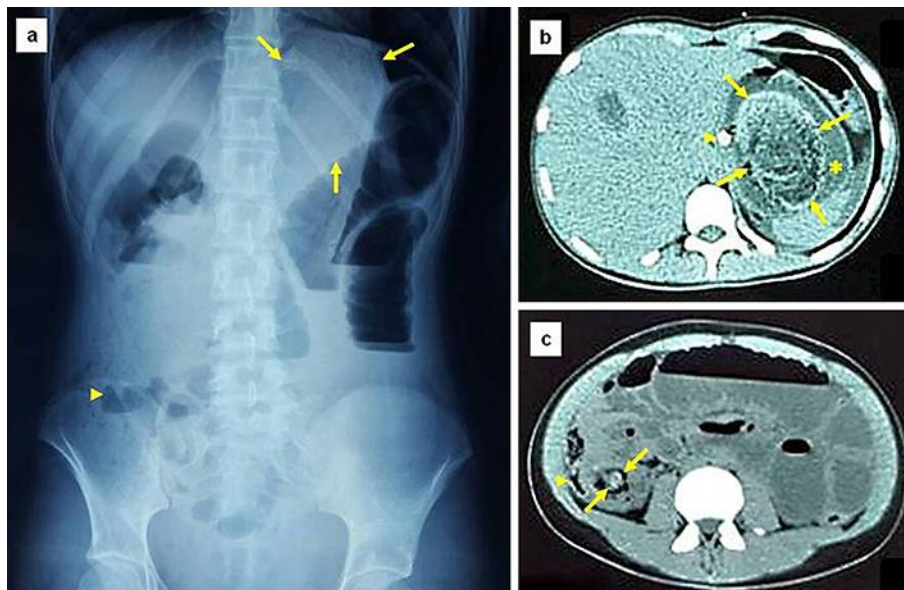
a Plain abdominal film showing a distended and occupied stomach (arrows), dilated small bowel loops and air-fluid levels, and distension of distal ileum (arrowhead). b CT scan demonstrating a large ovoid heterogeneous mass within the gastric lumen (arrows), surrounded by gastric fluid (asterisk). The nasogastric tube is also shown (arrowhead). c CT scan also showing dilated small-bowel loops and air-fluid levels proximal to a heterogeneous intraluminal mass causing obstruction at the ileocecal valve (arrows). The cecum is shown displaced and compressed by the dilated ileum (arrowhead). Both intraluminal masses are suggestive of trichobezoars.
